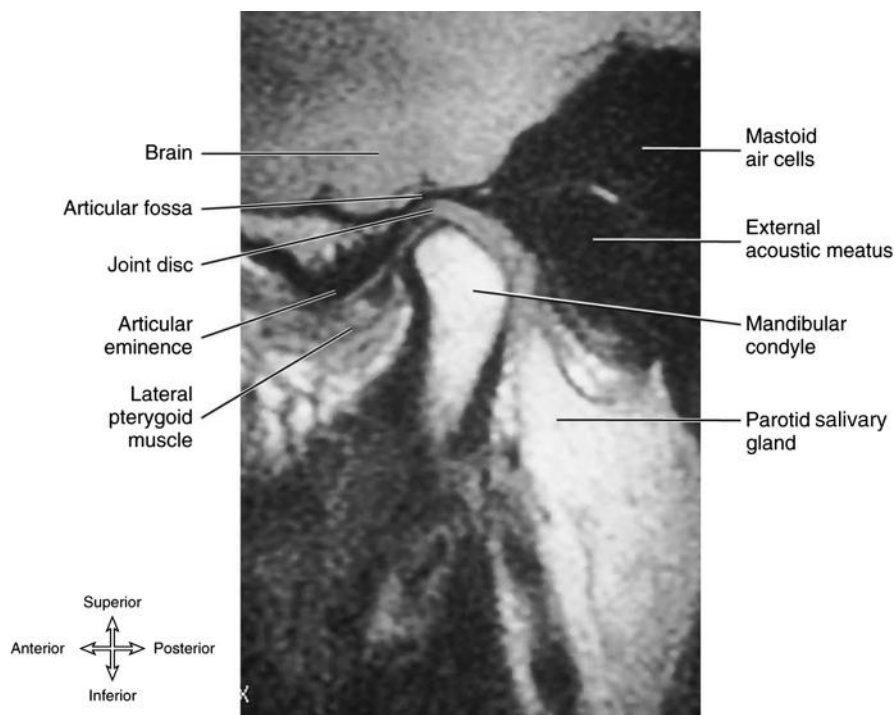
Coronal magnetic resonance imaging of the temporomandibular joint of an asymptomatic individual. (From Quinn PD: *Color atlas of temporomandibular joint surgery*, St Louis, 1998, Mosby/Elsevier.)
